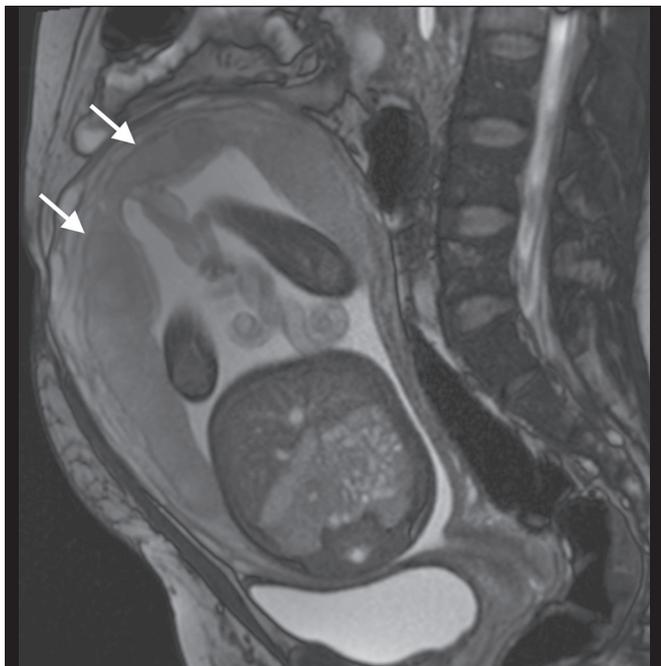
A 30-year-old patient with a normal placenta. Sagittal T2-weighted HASTE sequence showing an inverted pear-shaped uterus and a preserved myometrium-placenta interface (arrows).
